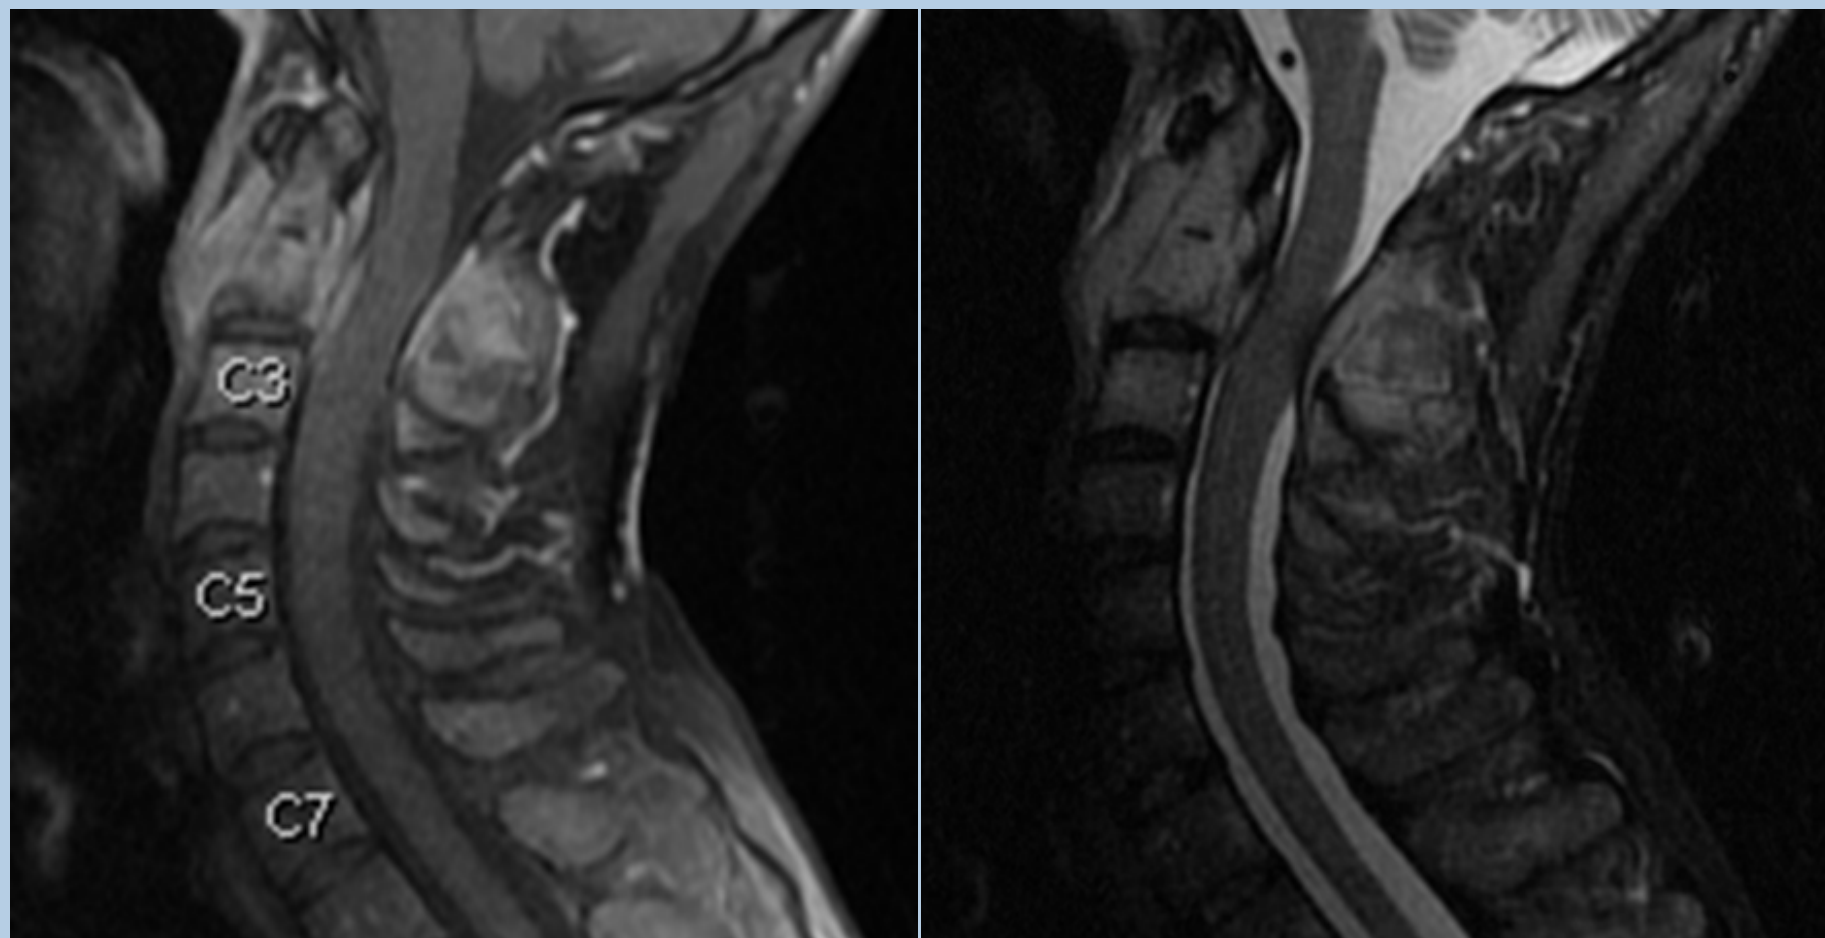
MRI neck June 2011
